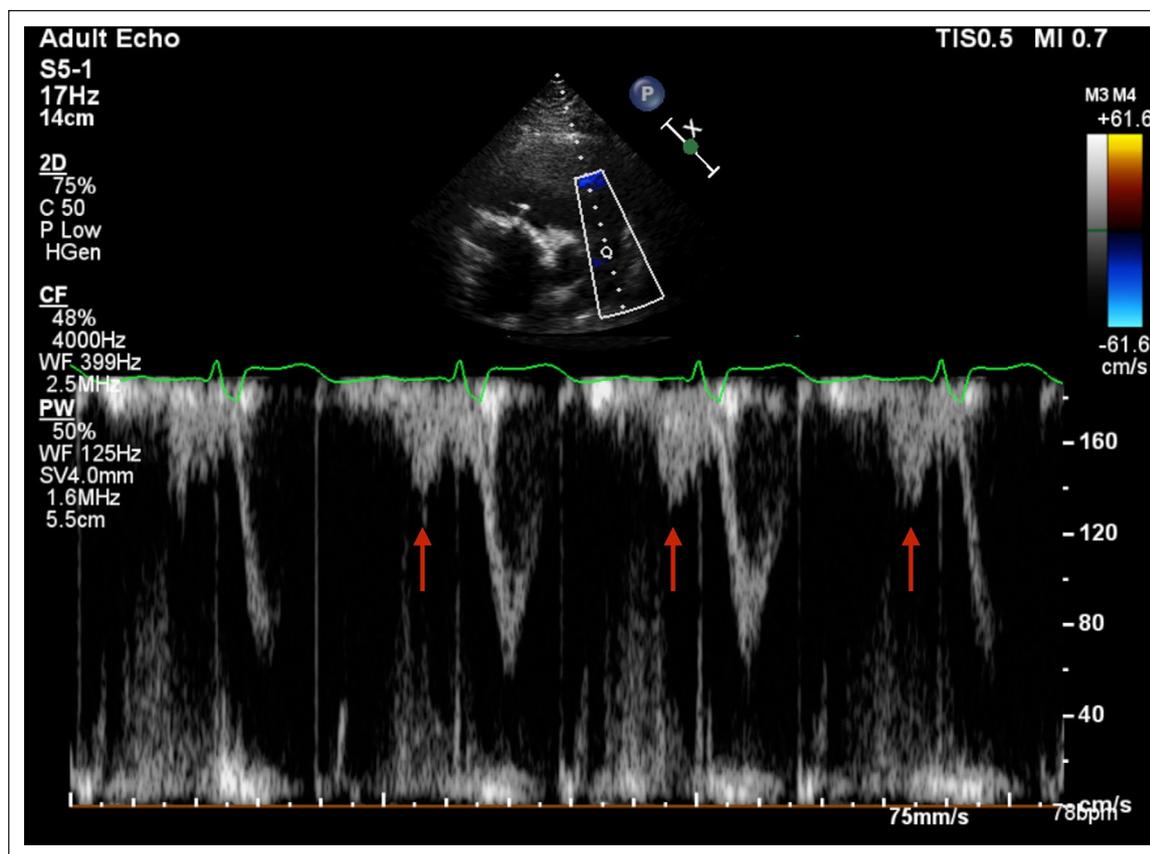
Pulse wave Doppler at the right ventricular (RV) outflow tract in short axis view sampling the flow through the pulmonary valve. Red arrows indicate the PV A wave, simultaneous at the atrial systole, preceding the RV systolic forward flow.
